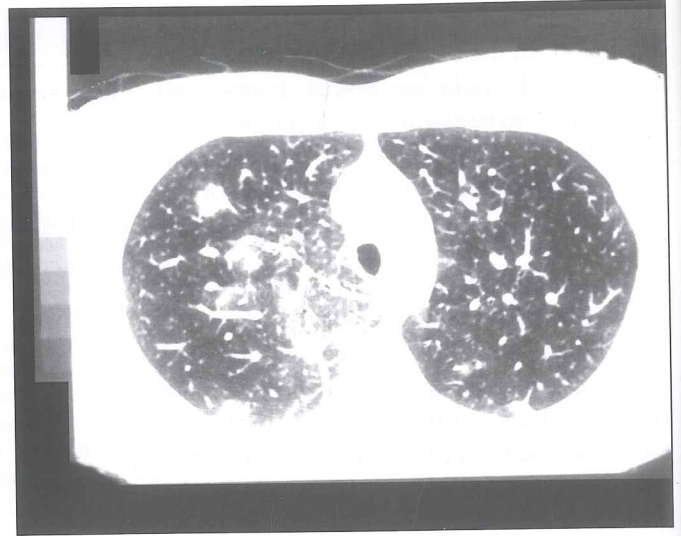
Bilateral patchy infiltrations in lung parenchyma (thorax HRCT).
